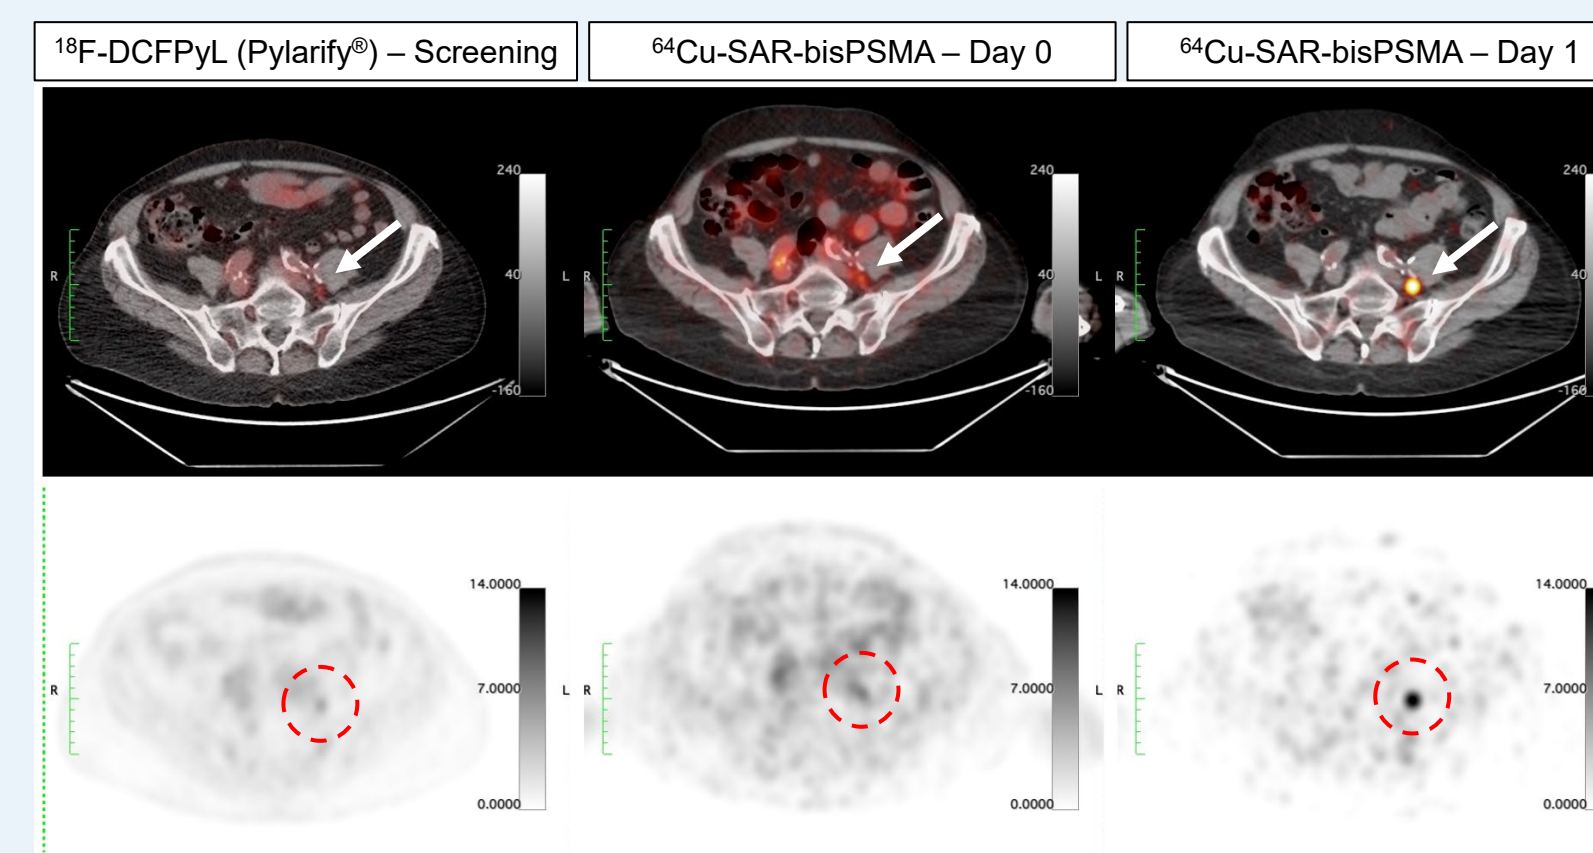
Identification of a lesion in the pelvic region using <sup>64</sup>Cu-SAR-bisPSMA on Day 1 imaging (right), negative on Day 0 imaging (center) and equivocal on screening <sup>18</sup>F-DCFPyL imaging (left). SUVmax of the lesion across scans (arrows in top images and red circles in bottom images) was 2.3, 4.3 and 17.5 (<sup>18</sup>F-DCFPyL Day 0 and Day 1 <sup>64</sup>Cu-SAR-bisPSMA, respectively). Top images: PET/CT fusion. Bottom images: PET.
